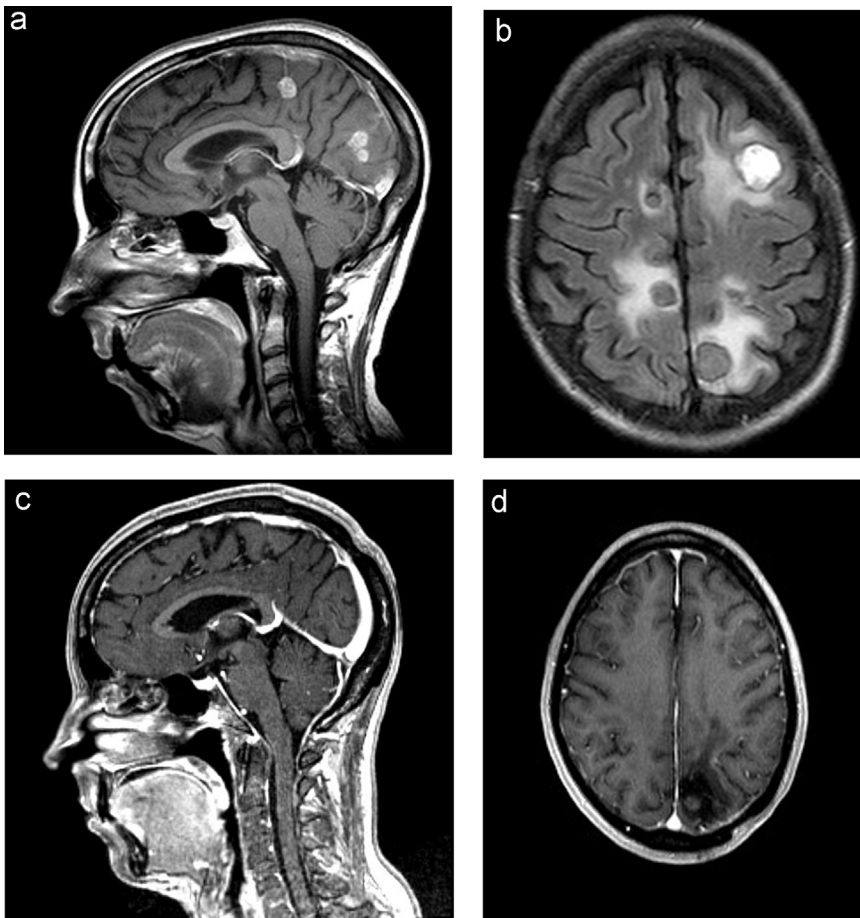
a, b: MRI in October 2004: The transversal Flair-weighted (a) and sagittal T1-weighted images (b) show multiple *Scedosporium apiospermum* brain abscesses. c, d: MRI in October 2009: The T1-weighted sagittal (c) and transversal (d) images show no brain abscesses but postoperative residual defect areas and gliosis zones can be seen.
